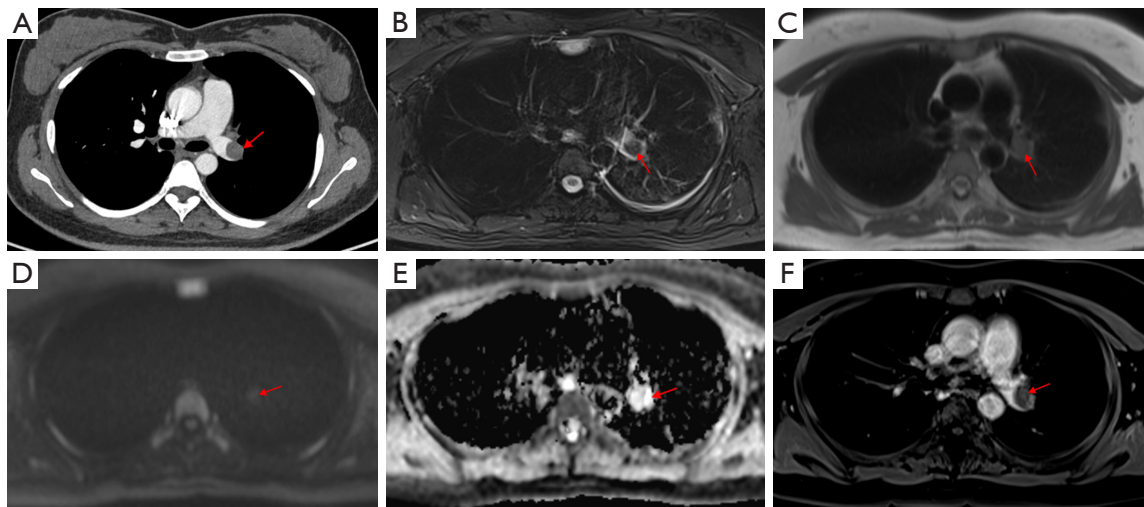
A 35-year-old man with a pathological diagnosis of chronic pulmonary thromboembolism. (A) Computed tomography pulmonary angiography showed a nodular filling defect in the left pulmonary artery (red arrow). (B) The lesion was hypointense on fat-suppressed T2-weighted imaging (red arrow). (C) T1-weighted imaging showed an isointense nodular lesion in the left pulmonary artery (red arrow). (D) On diffusion-weighted imaging ($b = 1,000 \text{ s/mm}^2$), the lesion was isointense (red arrow). (E) The lesion was hyperintense on apparent diffusion coefficient map (red arrow), indicating no diffusion restriction. (F) On enhancement imaging, the lesion was not obviously enhanced (red arrow).
